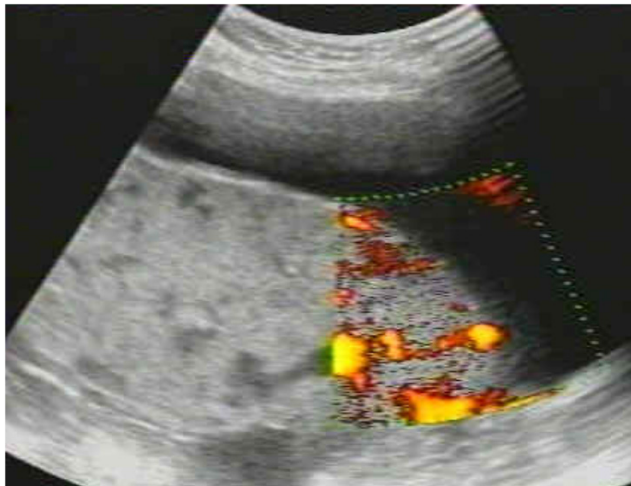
Irregular lacunae, increased vascularization, and turbulent flow on Doppler.
